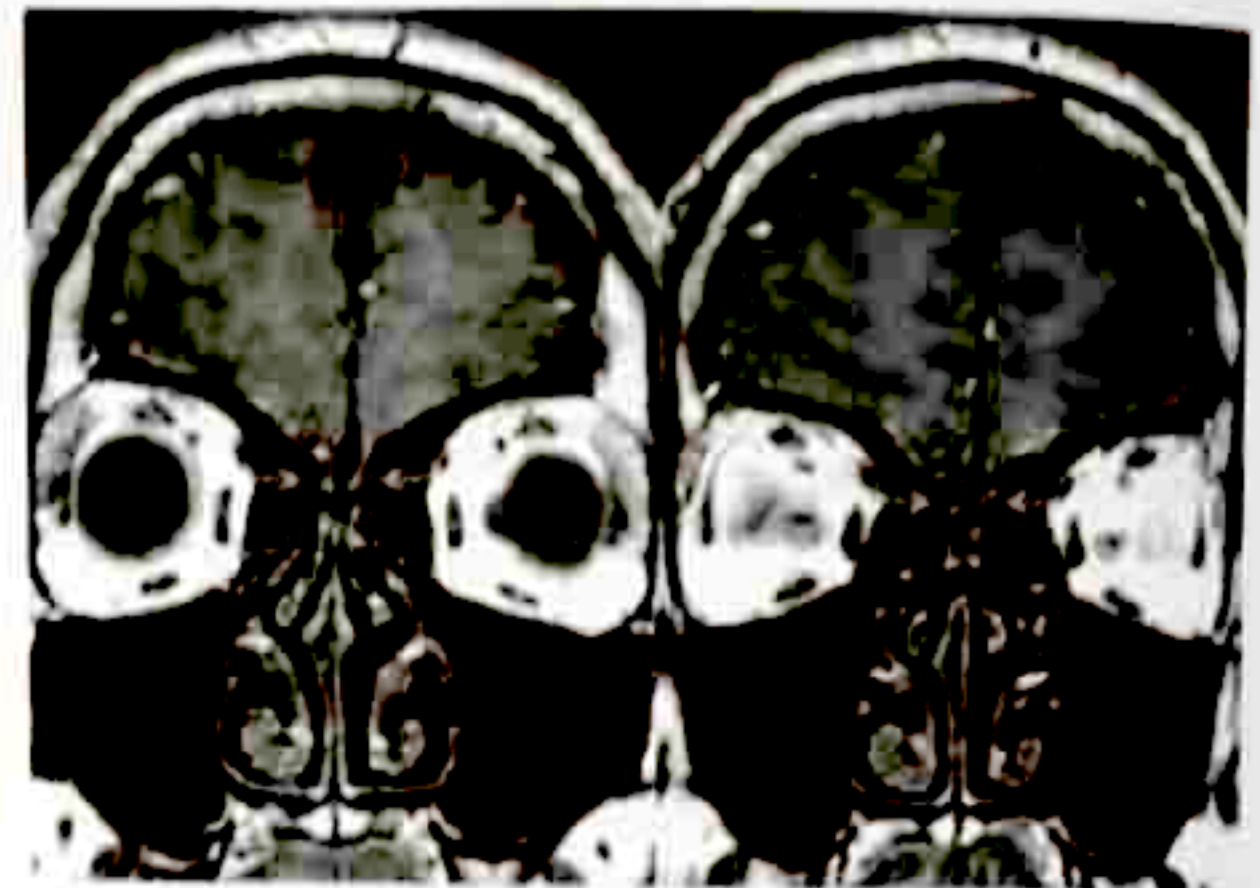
Coronal T1-weighted images of normal olfactory bulbs (arrow).
